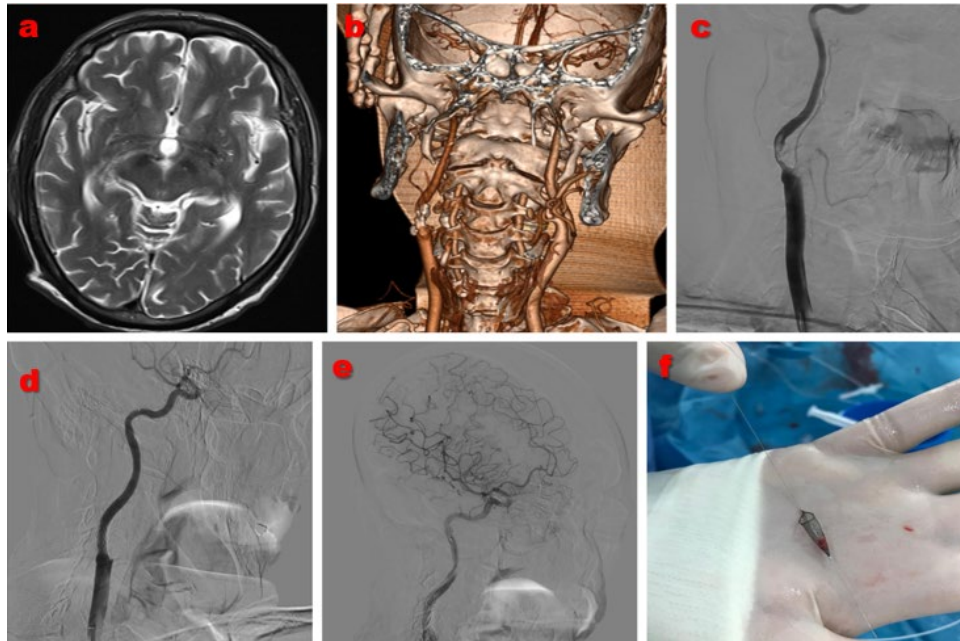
Imaging findings of a 75-year-old male patient presenting with transient ischemic attack (TIA). a) Cranial T2-weighted magnetic resonance imaging (MRI) showing no evidence of infarction. b) Three-dimensional computed tomography (CT) angiography revealing significant stenosis in the right internal carotid artery. c) Conventional digital subtraction angiography (DSA) image showing the stenosis and intraluminal thrombus. d) Post-stenting image demonstrating successful revascularization. e) No loss of intracranial arterial branches is observed. f) Image showing the thrombus captured in the distal embolic protection device.
